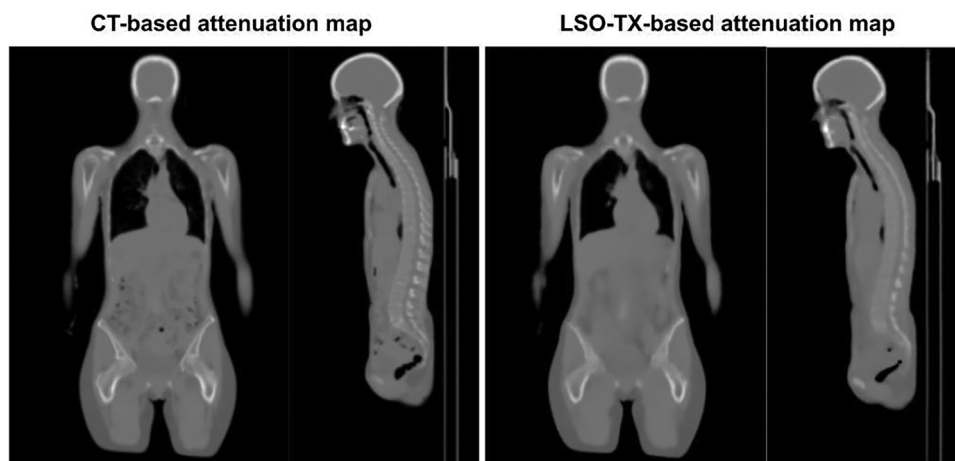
Comparison of attenuation maps using different methods: (Left) Standard attenuation image created by CT-based attenuation. (Right) attenuation image created using an LSO-Tx scan without CT, showcasing CT-free attenuation correction.
